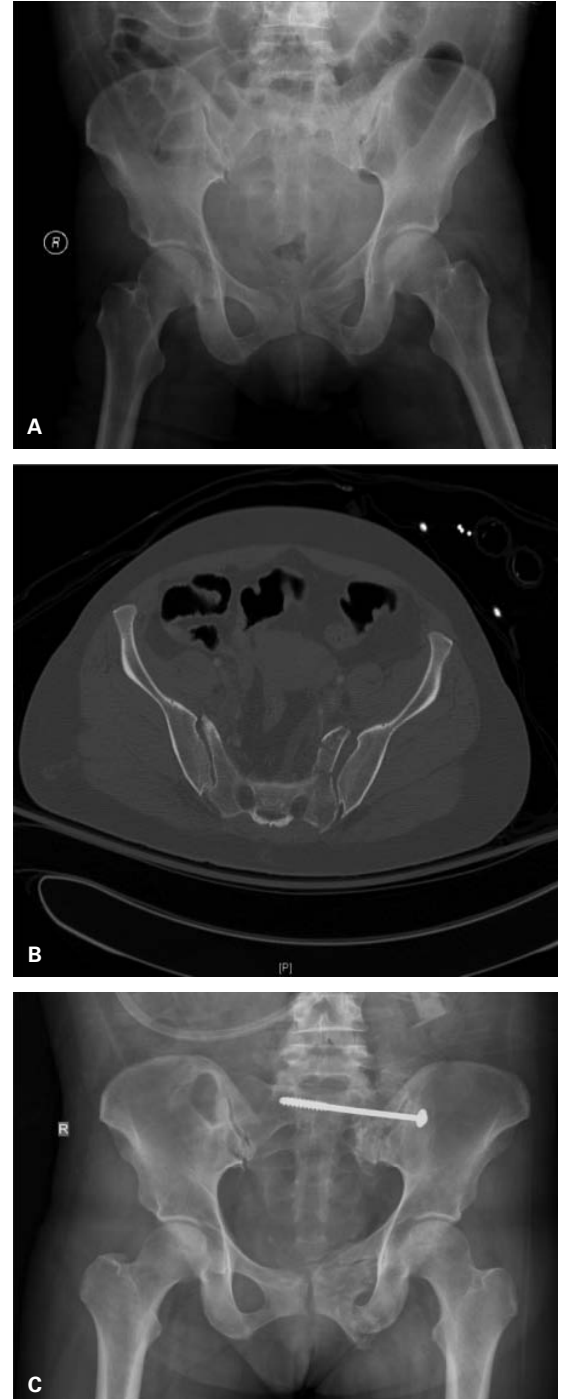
Pelvic radiograph (A) and CT scan (B) of a 49 year old female after a motor vehicle crash showing a displaced left inferior ramus fracture, superior ramus fracture, and a posterior ring injury which was treated with a sacroiliac screw (C).
